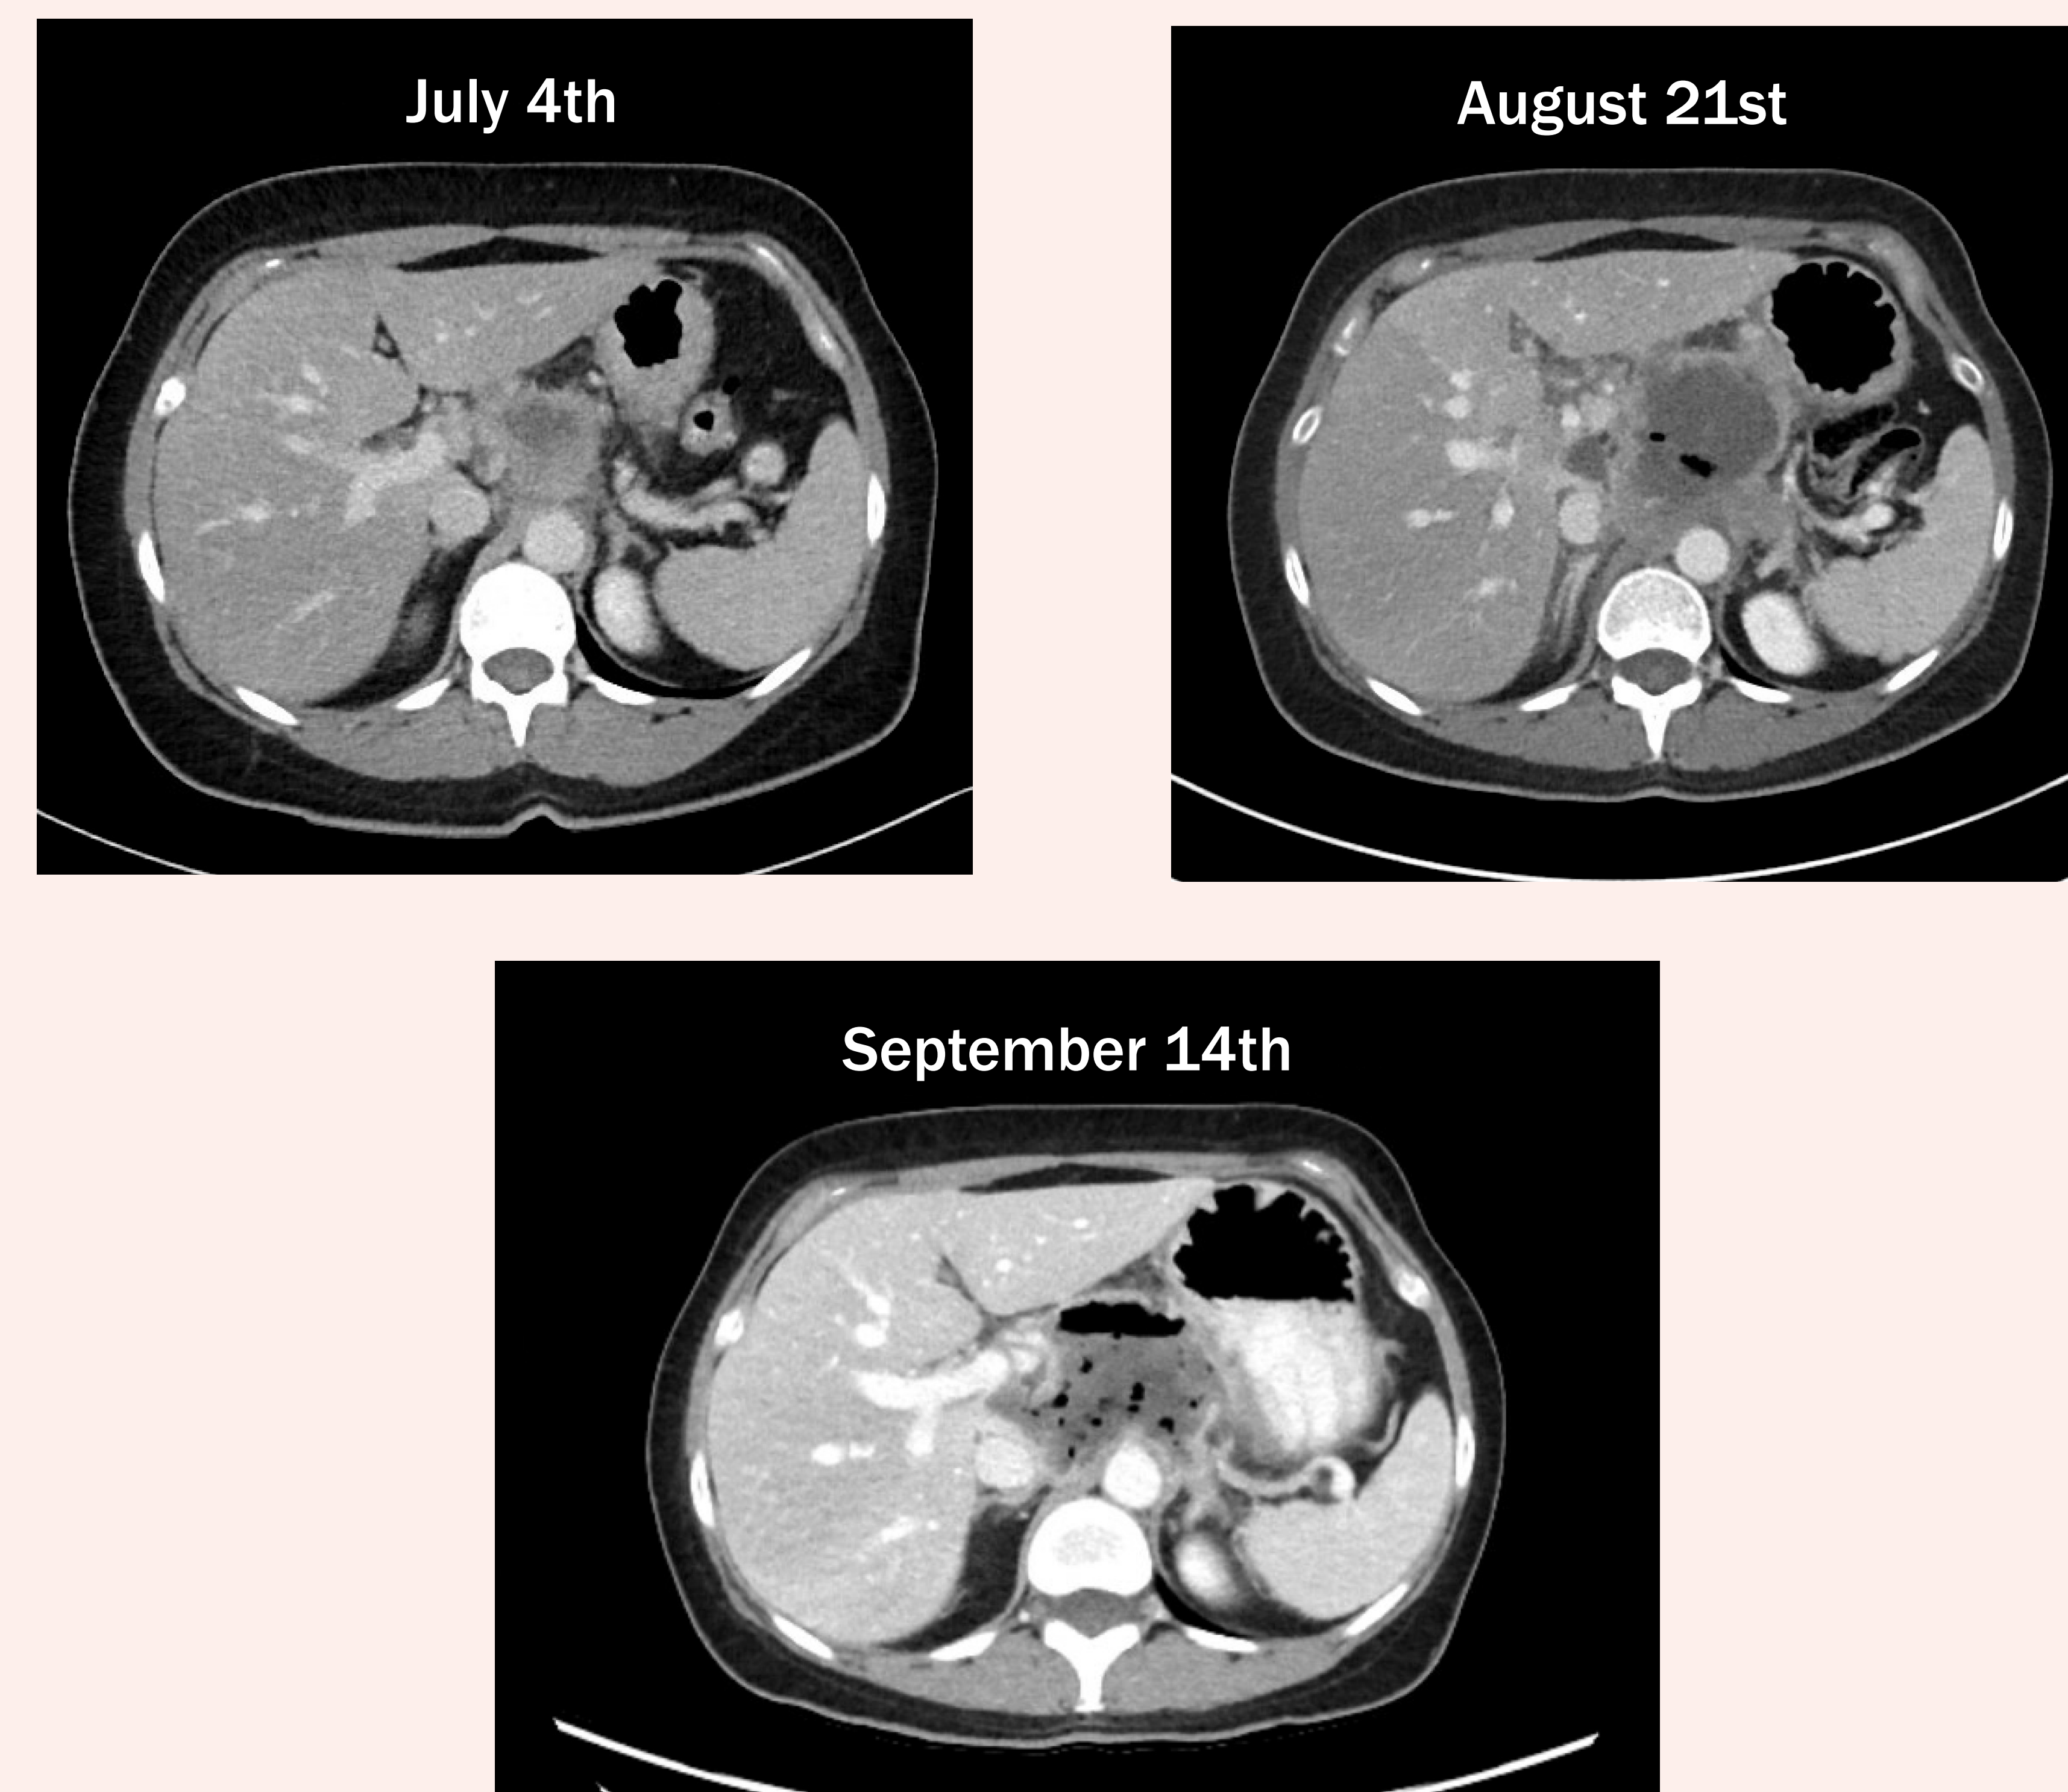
CT imaging showing progression of pancreatic mass over 3 months.
